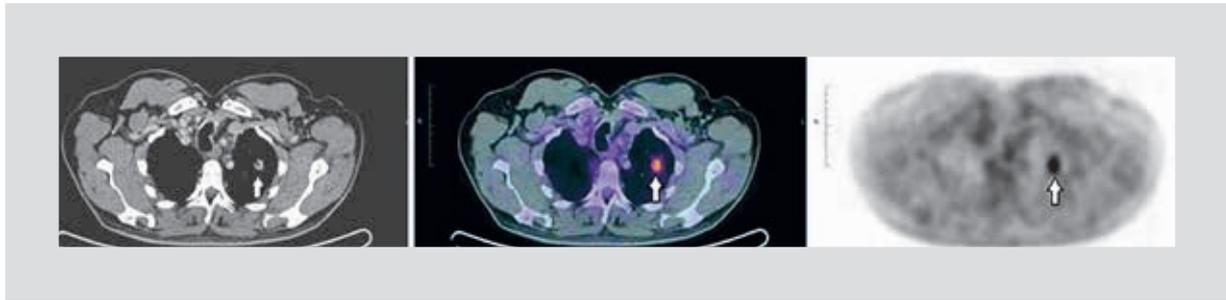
60-year old male diagnosed with rectosigmoid moderately differentiated adenocarcinoma, clinical stage IVA; surgery and chemotherapy were performed, with CEA elevation (60.6 ng/ml). ^{18}F FDG PET/CT scan showing highly uptaking lung parenchyma lymph nodes, with a SUV_{max} of 3.8 (white arrows).
